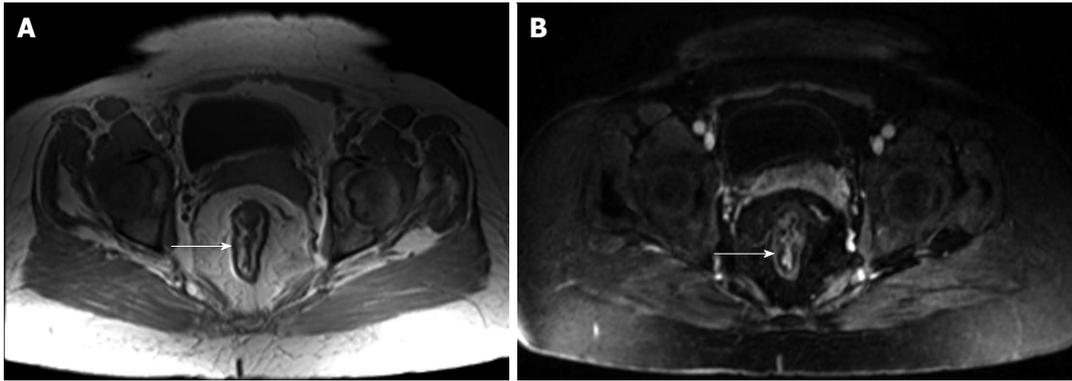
Chronic ulcerative colitis. A: Axial in-phase T1-weighted; B: Axial fat-suppressed post-gadolinium 3D-GRE T1-weighted images. There is diffuse rectal submucosal increased T1 signal (arrow, A), which demonstrates low signal on fat-suppression (arrow, B), but no significant arterial enhancement (B), in keeping with chronic ulcerative colitis. GRE: Gradient recalled echo.
